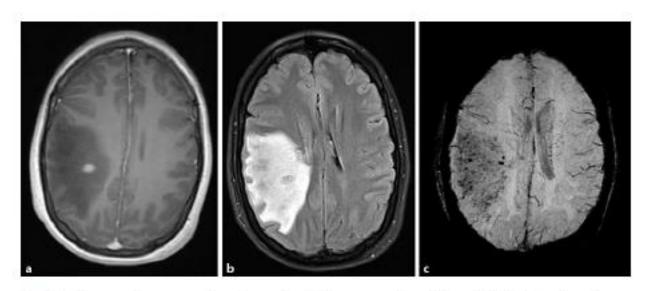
Brain magnetic resonance imaging on day 1 after presentation. a T1 + gadolinium showing a discrete area of contrast enhancement. b Fluid attenuation inversion recovery consistent with significant cerebral oedema. c Susceptibility-weighted imaging demonstrates multiple petechial haemorrhages.
